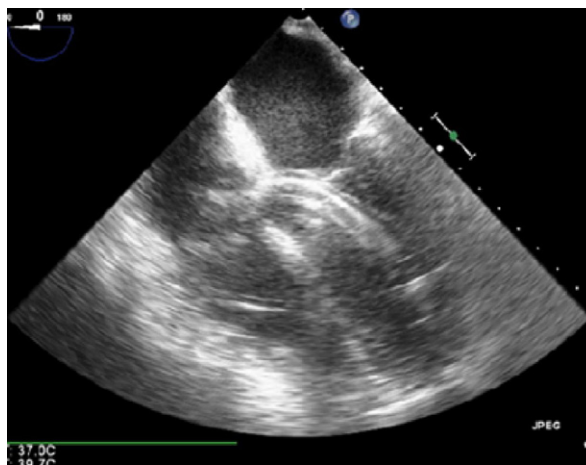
Transesophageal echocardiogram shows correct placement of the Impella device and consequent left ventricular decompression.
